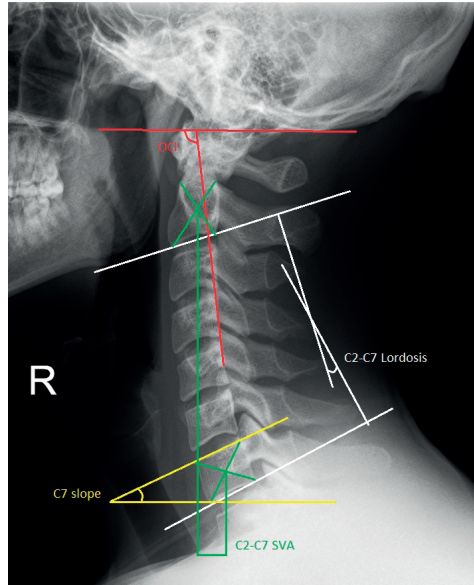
Radiographic evaluation of cervical sagittal alignment parameters
